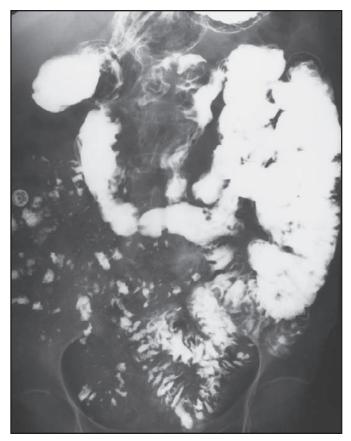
Small bowel X-ray showing findings of flocculation and segmentation of barium representing excessive fluid secretion in the lumen of the small intestine, thickened mucosal folds, and dilation of the small intestine. These are non-specific. Mayo Clinic Gastrointestinal Imaging (in press). Reprinted with permission of Mayo Foundation.
